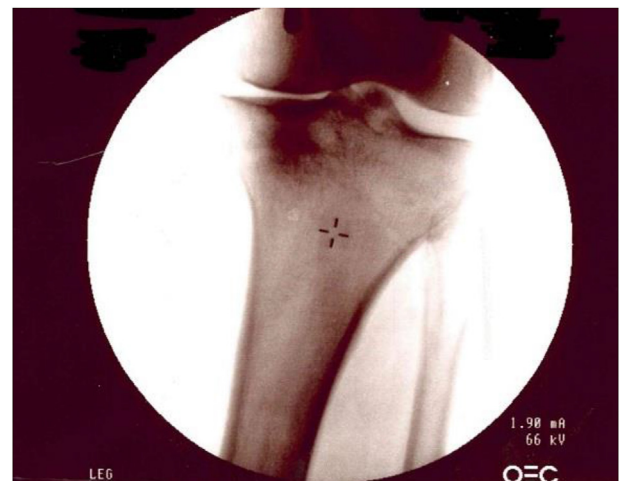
Levy technique of subchondroplasty, Lateral radiograph note probe marking joint line canula drilled from opposite side targeting area.
